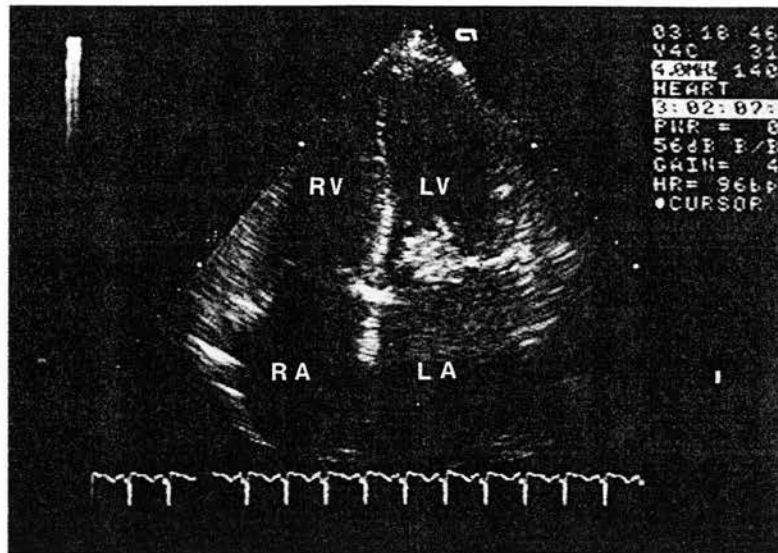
Transthoracic 2D gray-scale image of apical four-chamber view presenting SLE mass obstructing mitral valve orifice. (LA, Left atrium; RA, right atrium; LV, left ventricle; RV, right ventricle.)
